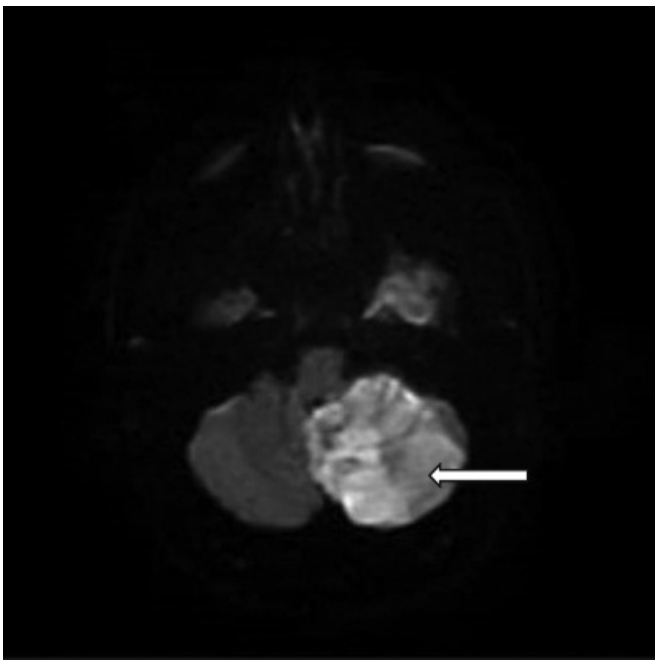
DWI sequence MRI brain left cerebellar infarction.
